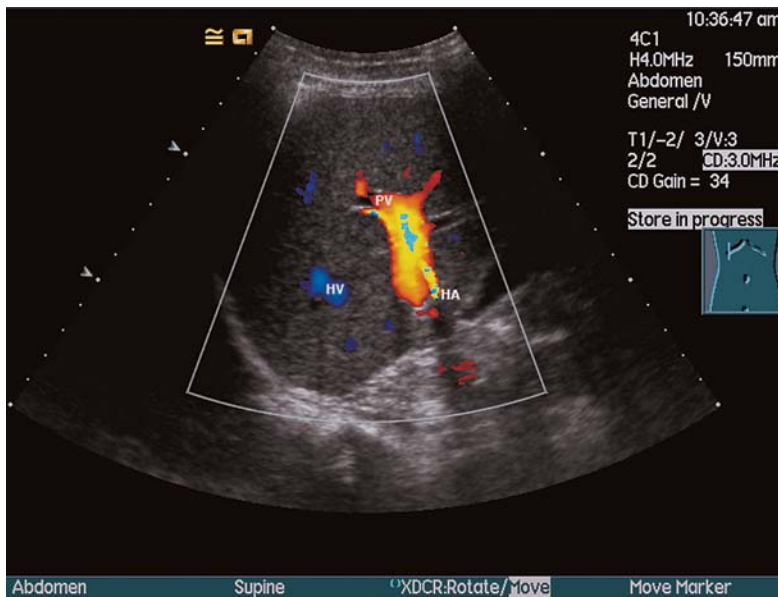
In colour Doppler, flow towards the transducer is coded in red-tinted colours so that both the portal vein and the hepatic artery have similar colours. Hepatic vein branches are seen in blue. HA, hepatic artery; HV, hepatic vein; PV, portal vein
